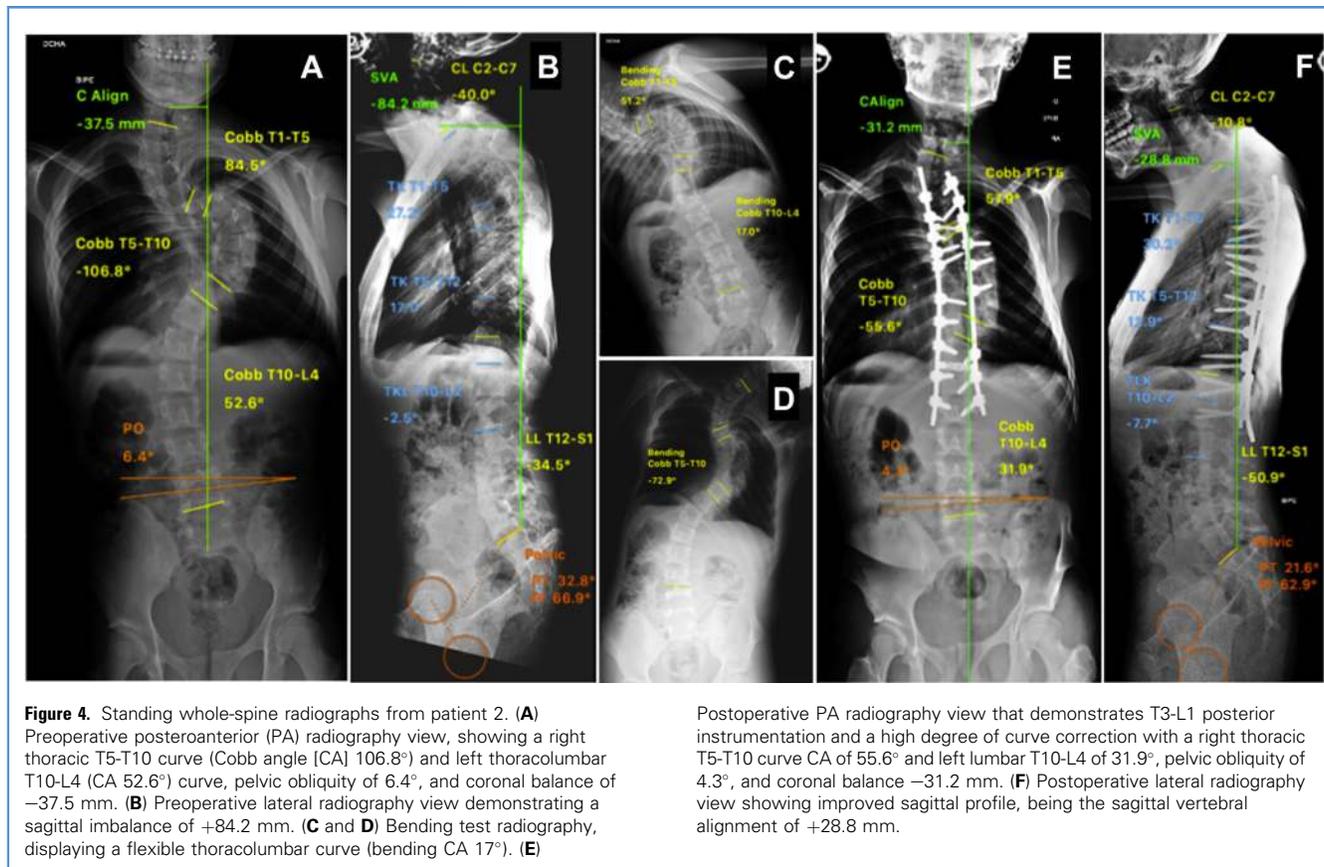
Standing whole-spine radiographs from patient 2. (A) Preoperative posteroanterior (PA) radiograph view, showing a right thoracic T5-T10 curve (Cobb angle [CA] 106.8°) and left thoracolumbar T10-L4 (CA 52.6°) curve, pelvic obliquity of 6.4°, and coronal balance of -37.5 mm. (B) Preoperative lateral radiograph view demonstrating a sagittal imbalance of +84.2 mm. (C and D) Bending test radiography, displaying a flexible thoracolumbar curve (bending CA 17°). (E)
